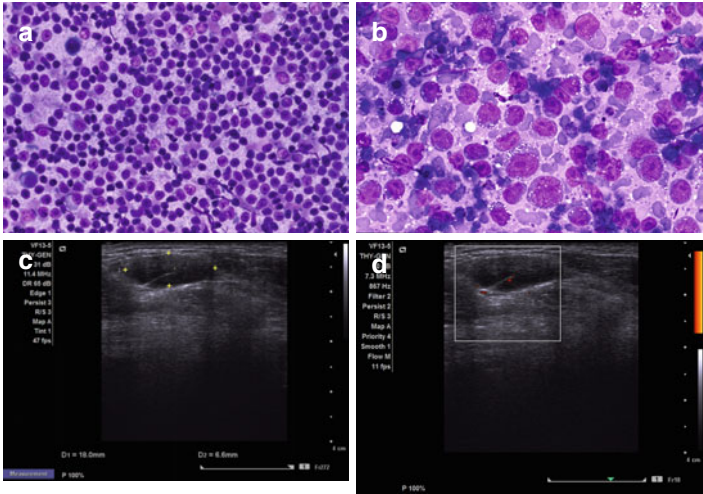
Small cell lymphocytic lymphoma. The smear shows a monotonous population of small round lymphoid cells (a). The precise diagnosis is made based on flow cytometric analysis. Large cell lymphoma transformation may occur (Richter lymphoma) and the vacuolated cytoplasm is often the result of prior chemotherapy (b). The US evaluation showed slightly enlarged cervical lymph nodes with linear hilum (c) and minimal blood flow by Doppler exam (d) (a, b DiffQuik, high magnification) (a From Pambuccian and Bardales (2011). Reprinted with permission)
